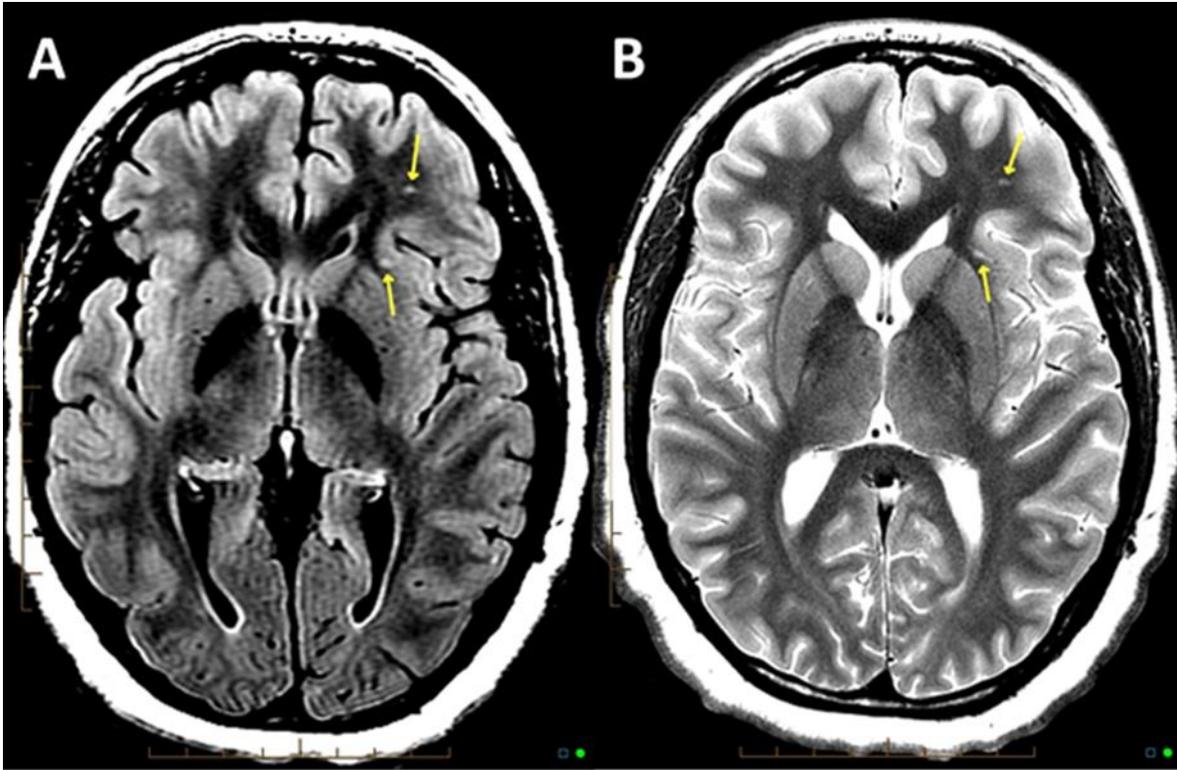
FLAIR (1A) and conventional T2 MRI (1B) showing two subcortical WMHs at grey-white matter junction in the left anterior frontal lobe of a 22 year old female diagnosed with mTBI.
